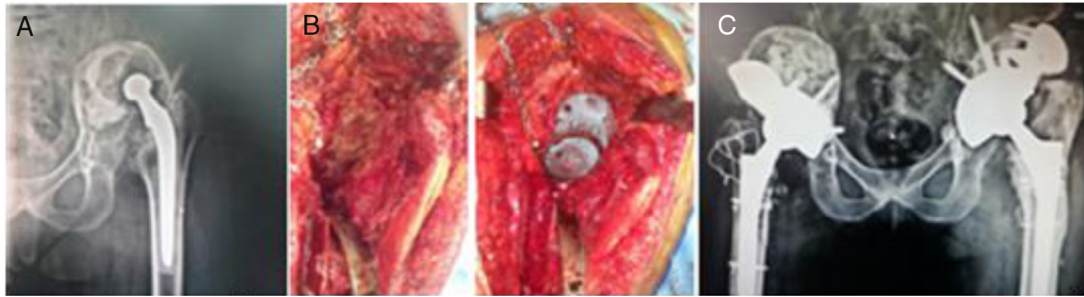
Bilateral revision of total hip arthroplasty. A, preoperative radiograph of the left hip showing severe acetabular defect (Paprosky 3B); B, perioperative imaging showing the use of trabecular metal wedge; C, panoramic postoperative radiograph of the pelvis.
